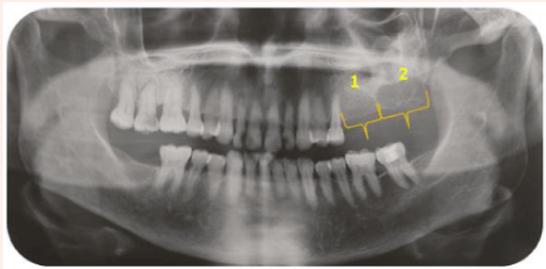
Orthopantomography with two left maxillary Keratocysts (numbered and marked with braces).
